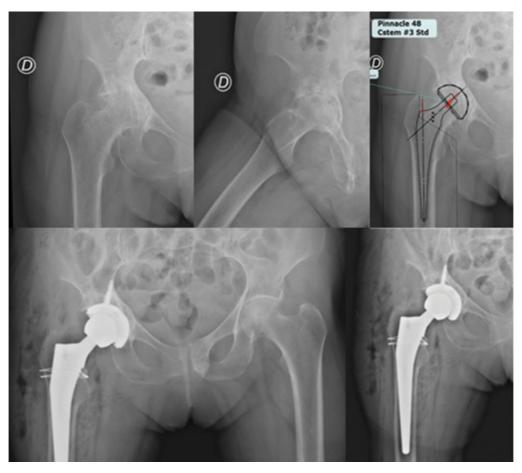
Preoperative planning for a patient with acetabular protrusion. Postoperative radiograph with deformity correction as planned.
